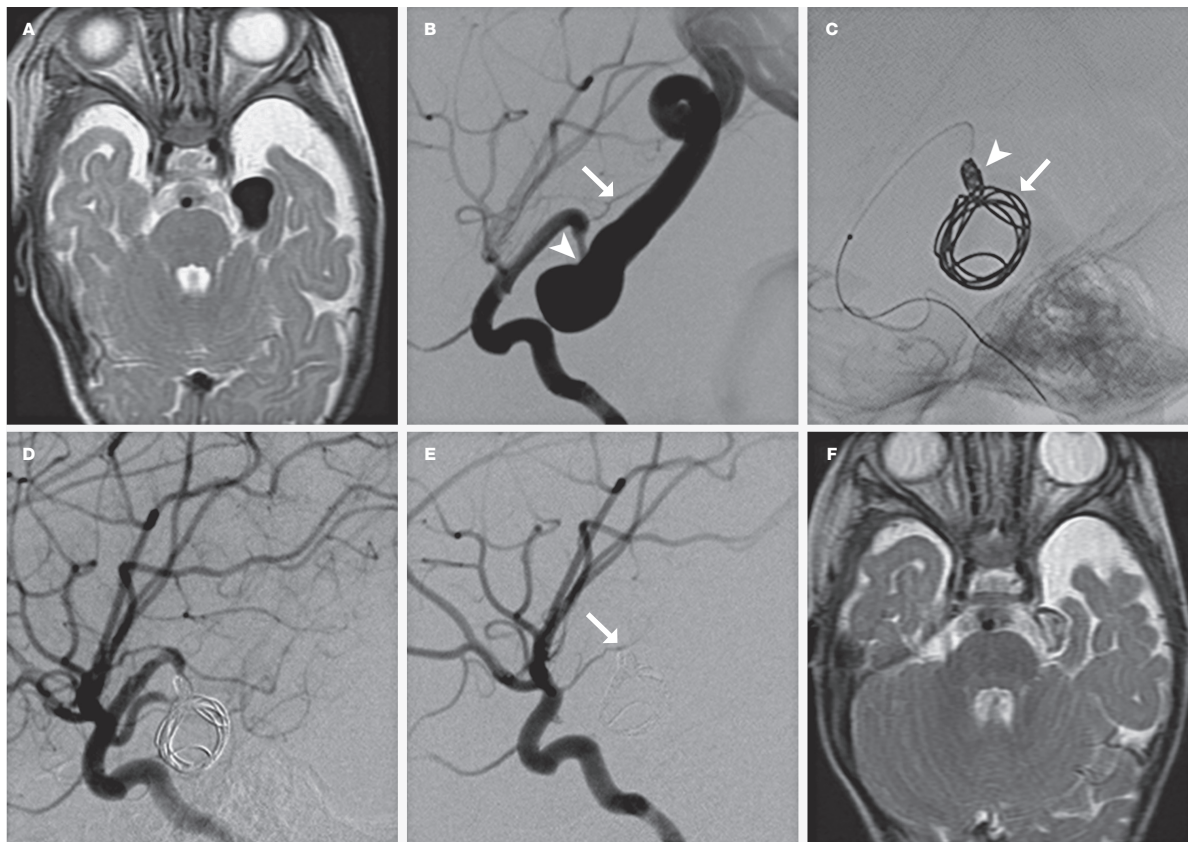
A) T2-weighted MR imaging reveals a low intense flow void located medial to the left temporal lobe. B) Lateral view of the left internal carotid angiogram demonstrates the AVF fed by the dilated left AChOA shunting to the ipsilateral basal vein of Rosenthal. The distal AChOA (arrow) originated just proximal to the fistula point (arrowhead). C) Lateral plain craniogram shows a single anchor coil (arrow) in the varix and 3 additional coils at the fistulous point (arrowhead). D) Post-embolization left internal carotid angiogram shows complete obliteration of the AVF. E) Left internal carotid angiogram 3 months after the embolization revealed no recanalization of the AVF and normalization of the AChOA. F) T2-weighted MR imaging at the same time showed shrinkage of the varix.
